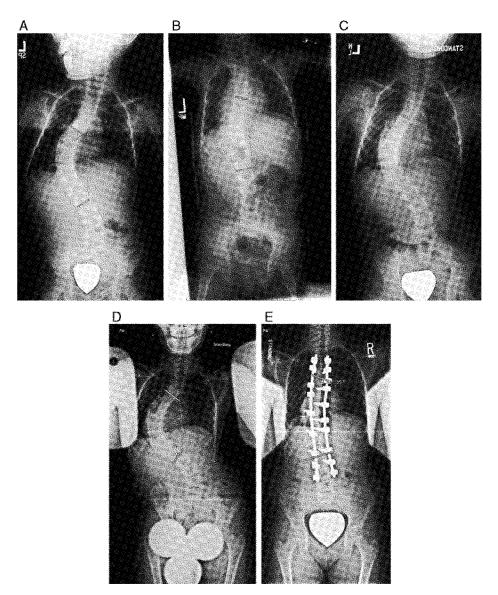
Child initially casted at age 3 years 3 months for progressive idiopathic scoliosis despite brace treatment. A and B, Precast and postcast x-rays at age 3 show good correction in a cast. C, The patient was transitioned to a brace for a short break in casting before being transitioned back into a cast at age 5. D and E, Curve progression occurred and the child underwent anterior thoracoscopic release and posterior spinal fusion at age 10 years 6 months. The total delay between initial casting and surgery was 87 months.
